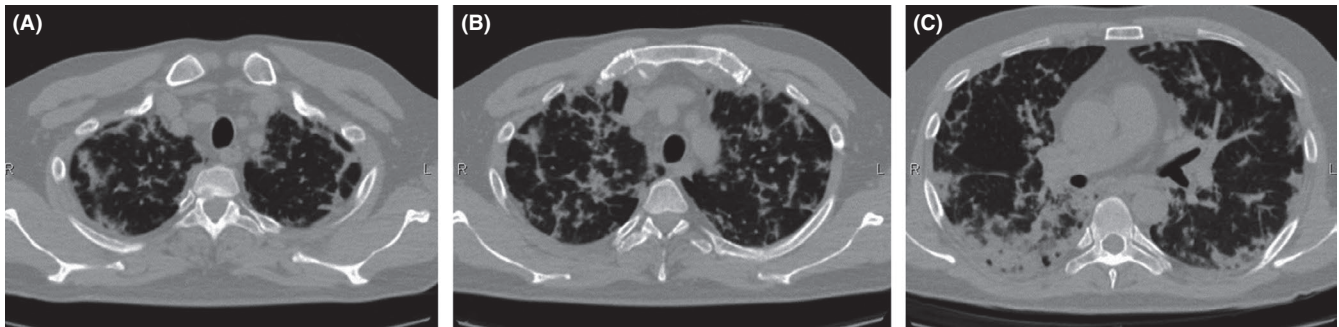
The CT scans show that previously recorded foci had consolidated, decreased in size, and increased in density
